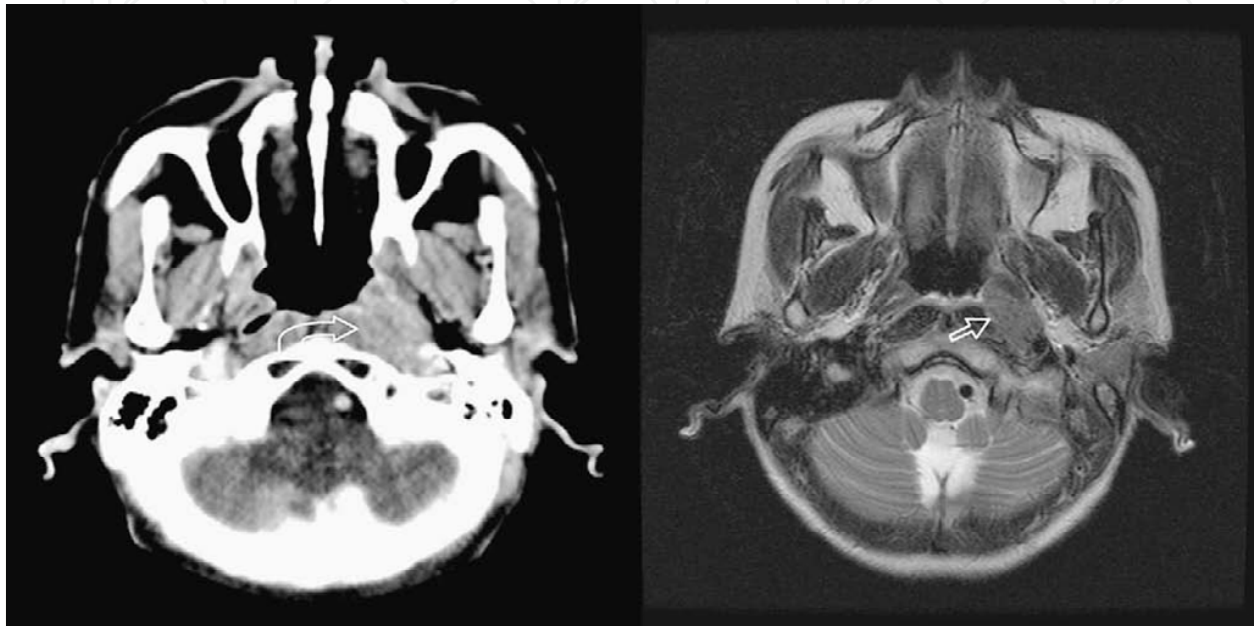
CT (left) and MRI (right) scan of nasopharyngeal cancer. MRI provides information in prevertebral muscle invasion better than CT scan (arrow)
